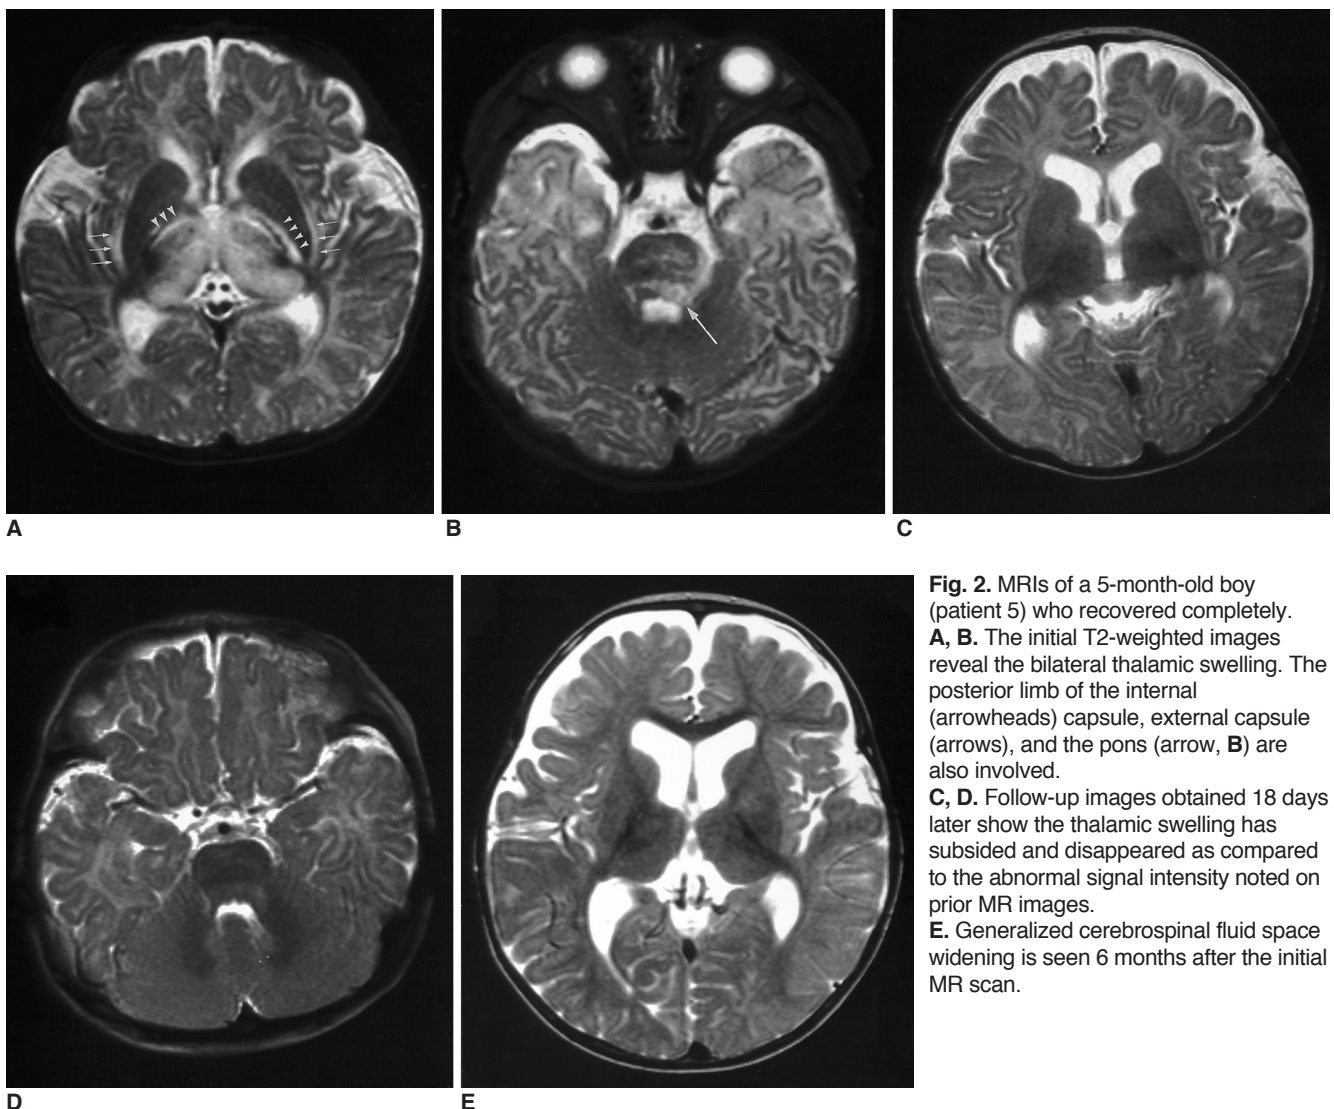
MRIs of a 5-month-old boy (patient 5) who recovered completely. A, B. The initial T2-weighted images reveal the bilateral thalamic swelling. The posterior limb of the internal (arrowheads) capsule, external capsule (arrows), and the pons (arrow, B) are also involved. C, D. Follow-up images obtained 18 days later show the thalamic swelling has subsided and disappeared as compared to the abnormal signal intensity noted on prior MR images. E. Generalized cerebrospinal fluid space widening is seen 6 months after the initial MR scan.
